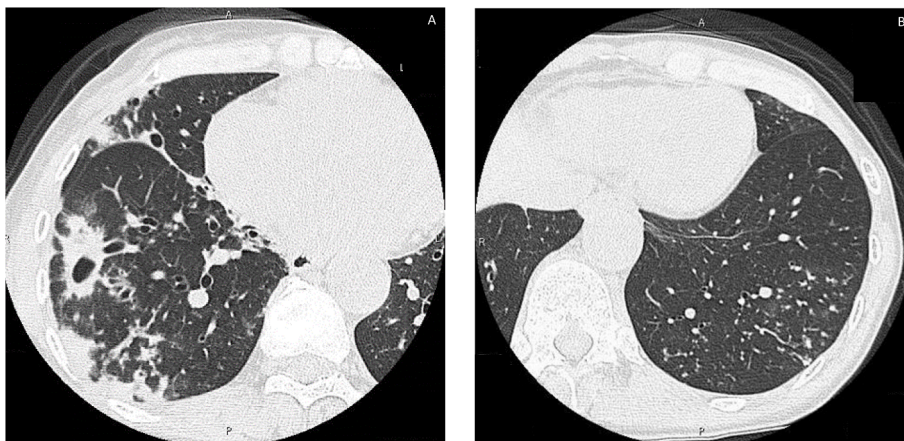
Chest CT shows fibrocavitary disease in the right lower lobe (A) and nodules in the left lower lobe (B).
